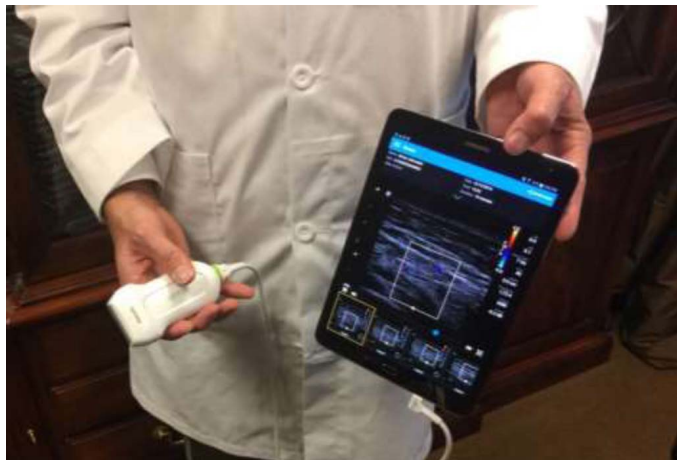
Portable Ultrasound probe and Tablet: Lumify by Philips.
